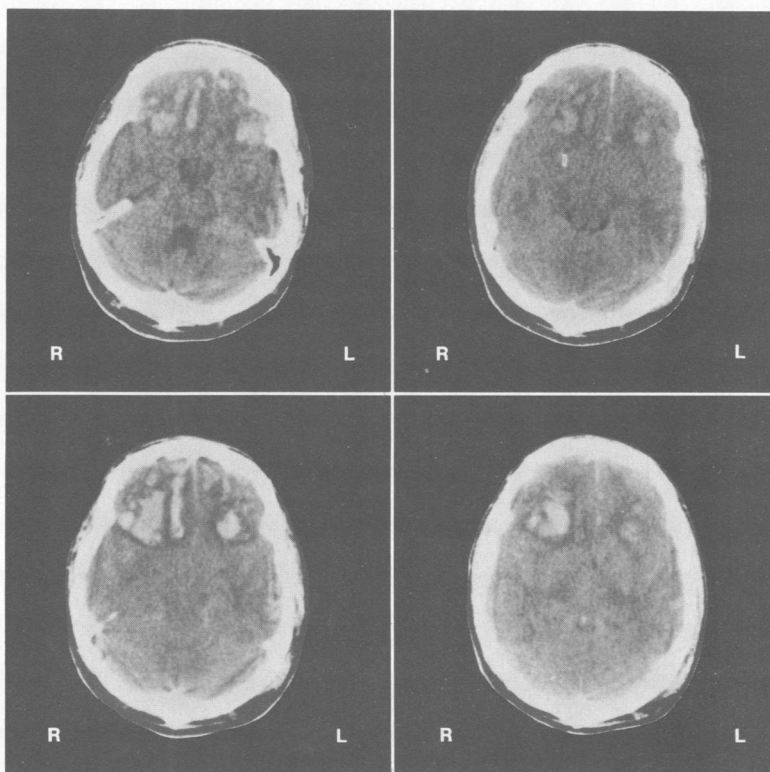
Top, Computed tomographic (CT) scans were taken of a 23-year-old man struck in the occipital region with resultant bilateral contrecoup lesions. On presentation, the patient was conversant but had deteriorated within 36 hours, becoming obtunded and posturing intermittently. Bottom, The CT scans show consolidation and enlargement of hemorrhagic tissue. Management elsewhere included hyperventilation and the administration of steroids without surgery. Shortly after the second scan, the patient had herniation of his brain and died.
